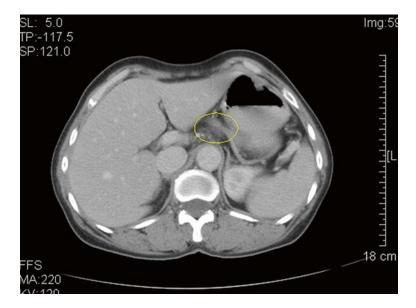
The CT image of LNs in the suprapancreatic area before the neoadjuvant chemotherapy (the *circle* represents the swollen LNs in the suprapancreatic area)
